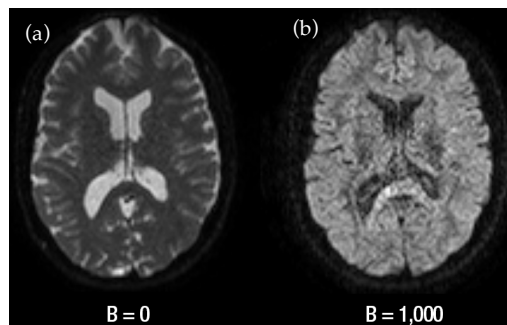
Image acquired with diffusion MRI. In the left image, panel (a), diffusion is not taken into account ($B=0$) while the right image, panel (b), is a diffusion weighted image ($B=1000$). Image taken from Diffusion Tensor Imaging (DTI) - Fiber Tracking - Imagilys. (n.d.). Retrieved January 24, 2020, from <https://www.imagilys.com/diffusion-tensor-imaging-dti/>
